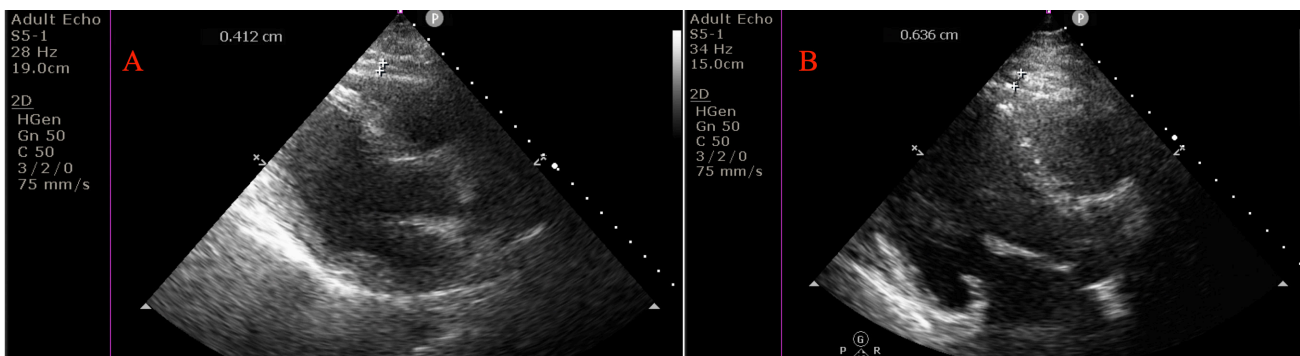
Measurement of epicardial fat thickness (EFT) in an euthyroid subjects (EFT = 0.4 cm) (A), and in a patient with subclinical hypothyroidism (EFT = 0.6 cm) (B). Epicardial fat thickness (EFT) perpendicular to right ventricular free wall. EFT identified as an echo-free space between the myocardium and visceral pericardium from the parasternal long-axis view on two-dimensional echocardiography, was measured perpendicularly in front of the right ventricular free wall at end-diastole.
